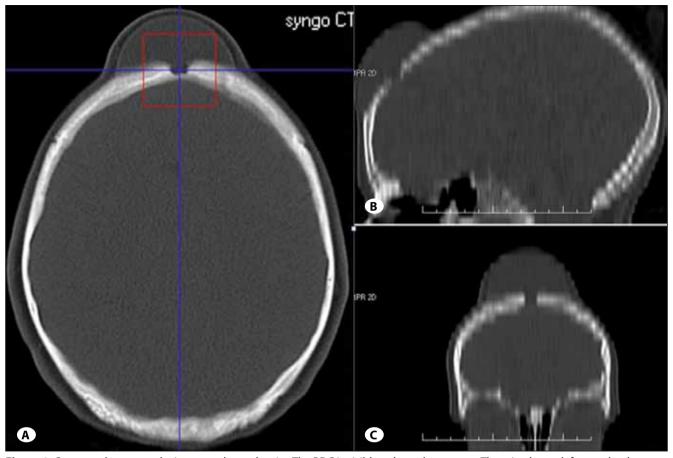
Computed tomography image on bone density. The BDC is visible as hypodense mass. There is a bony defect under the mass seen on all planes. A) Axial image, B) Sagittal reconstructed image, C) Coronal reconstructed image.
